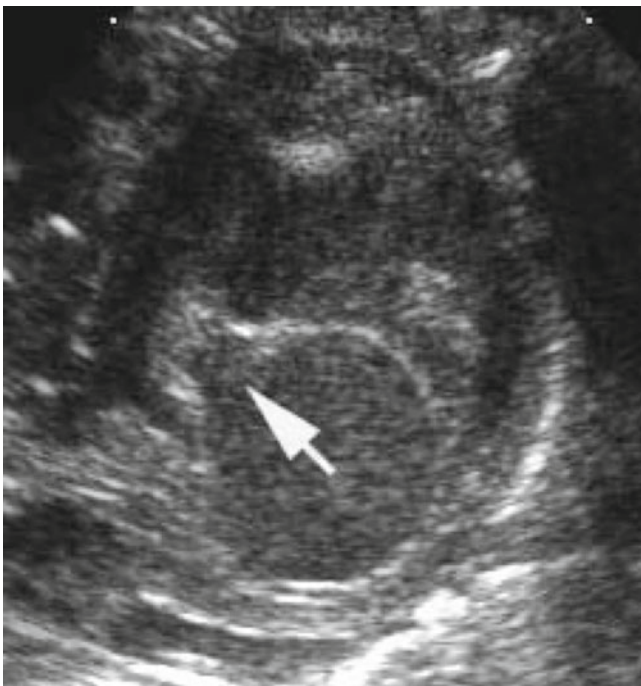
Transthoracic parasternal short axis image demonstrating a cleft in left atrioventricular valve (*arrow*) pointing toward the inlet septum in an atrioventricular septal defect
